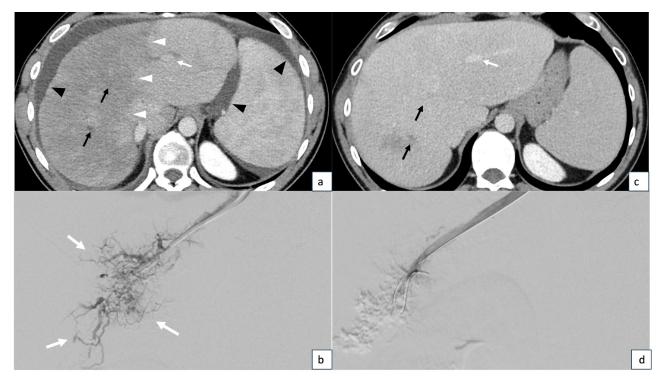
a) An axial computed tomography image shows thrombotic occlusion of the right and middle hepatic vein (black arrows), and a patent left hepatic vein (white arrow). This outflow obstruction led to acute perfusion changes in the right liver lobe (white arrowheads). The presence of ascites (black arrowheads) indicates acute portal hypertension. b) Angiography trough a 5 French catheter advanced in the occluded middle hepatic vein shows spiderweb like venous collaterals (arrows), indicating Budd-Chiari Syndrome. c) An axial computed tomography image 4 months after the procedure shows reocclusion of the right and middle hepatic vein (black arrows), and a patent left hepatic vein (white arrow). There is compensatory hypertrophy of the left liver lobe, and there are no residual signs of portal hypertension. d) Completion angiography after aspiration thrombectomy shows restored in-line flow in the middle hepatic vein, with absence of venous collaterals.
